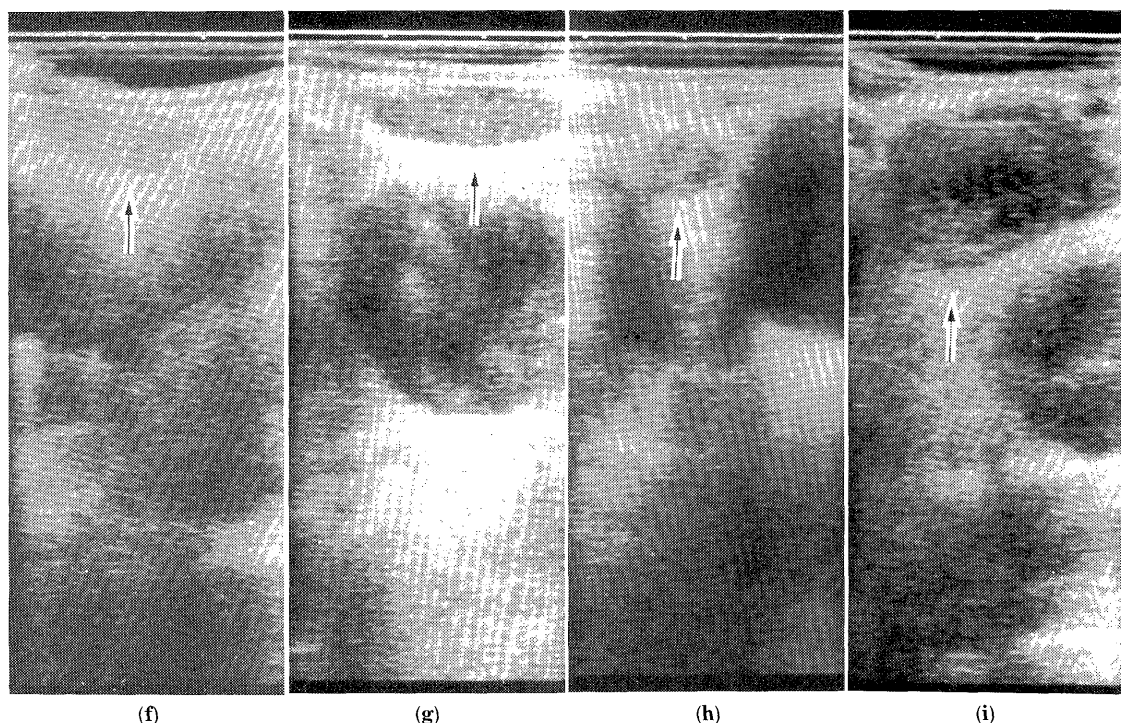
Endoscopic ultrasonograms of lymph node (f), (g), (h), and (i)
